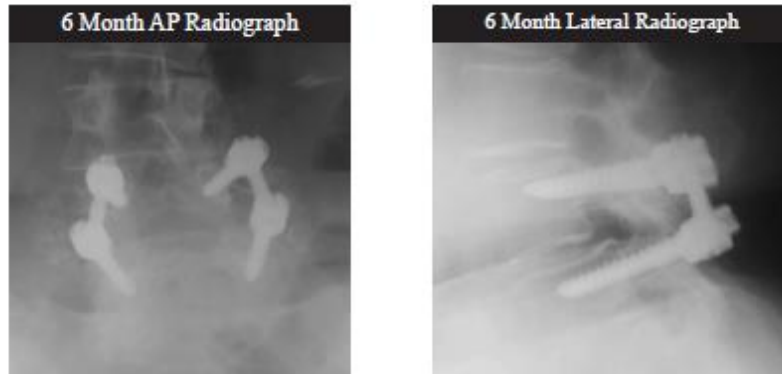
Radiograph imaging of NB
